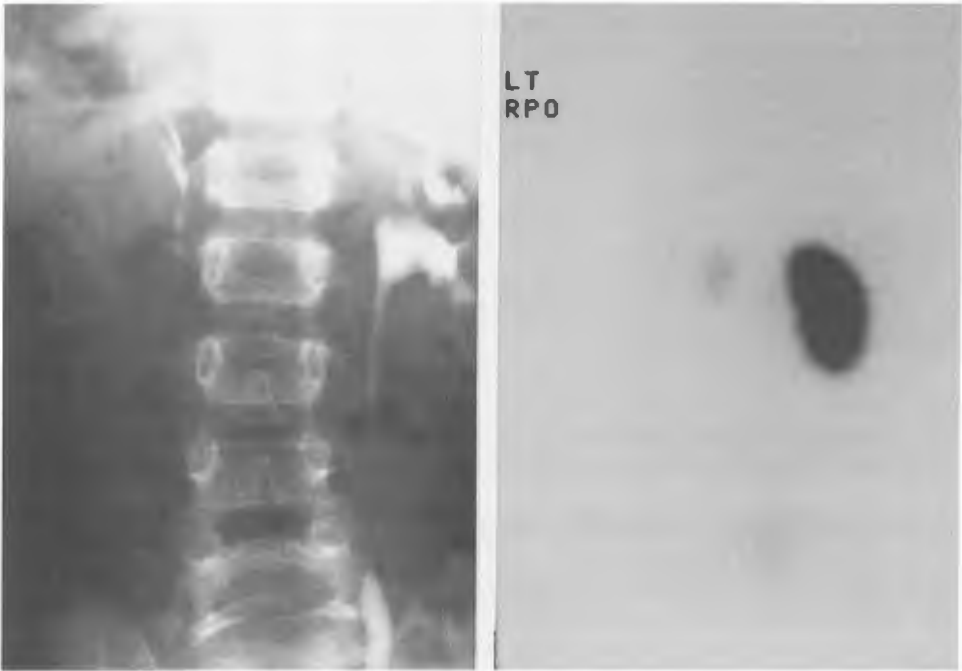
Hypoplastic and dysfunctional right kidney on intravenous pyelography (left) and renal scintigraphy (right).
